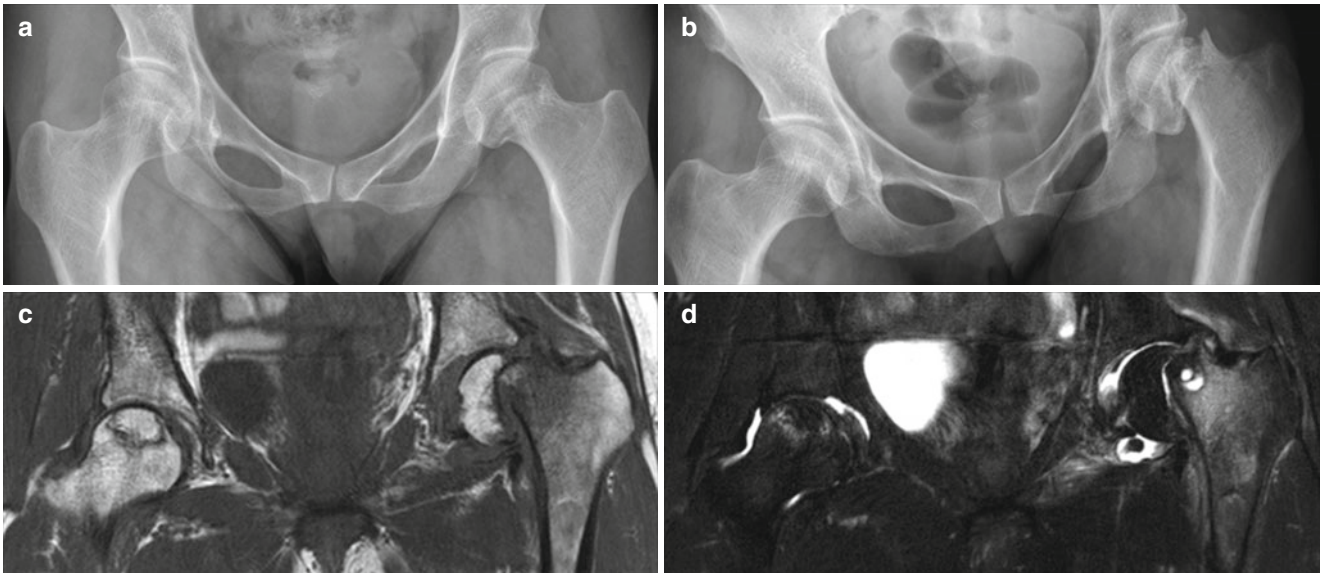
Pathologic fracture of ON in a 45-year-old female patient. (a) Both femoral heads show amorphous sclerosis. The junction of the left femoral neck and the head shows acute angulation. (b) Two months later, the left femoral head shows pathologic fracture with inferomedial displacement of the femoral head. (c) T1-weighted coronal image
